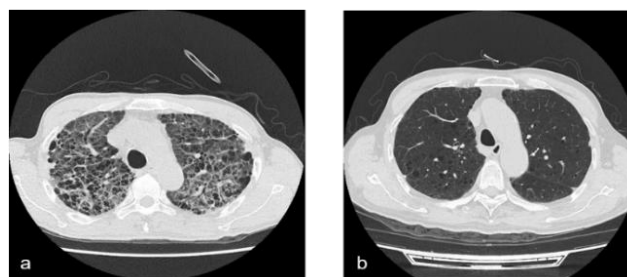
A male patient, aged 66, who presented with methotrexate-induced interstitial lung disease. (a) HRCT on ICU admission revealed diffuse ground glass inflammatory change. (b) HRCT showed improvement of bilateral ground-glass change after treatment in ICU.
